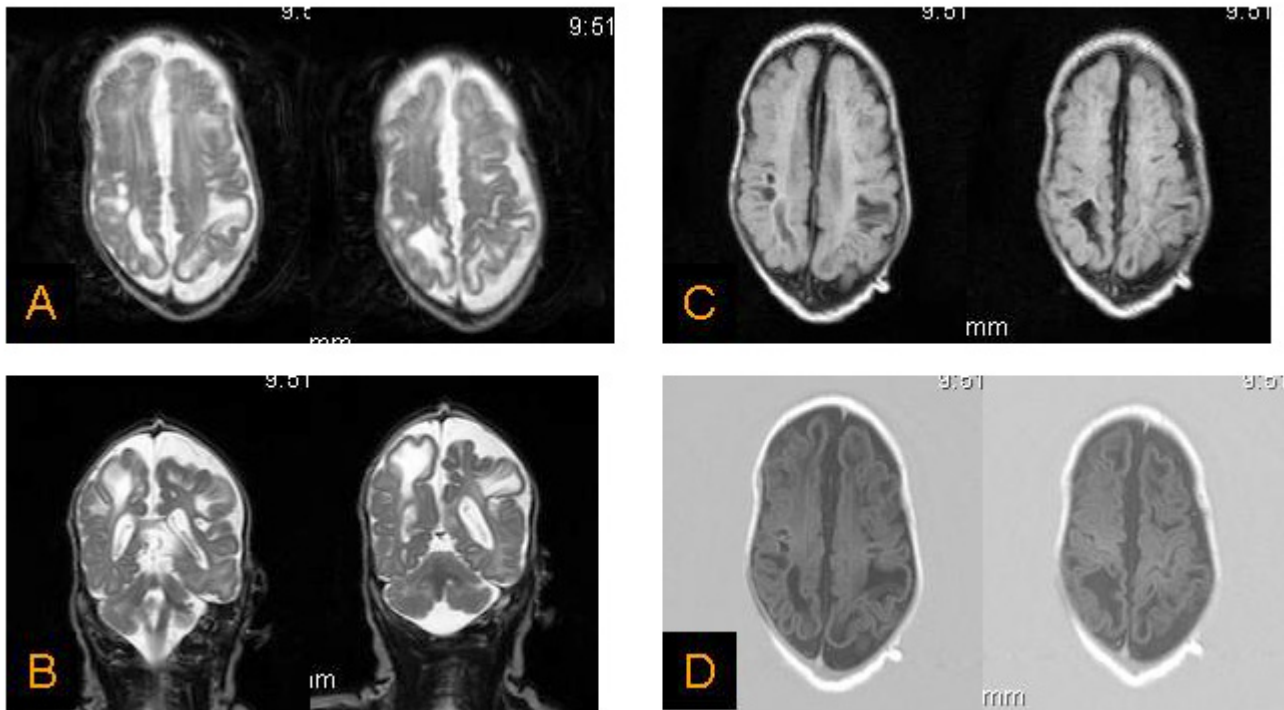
Brain MRI shows widespread posterior predominant subcortical cystic white matter changes and white matter hyperintensities. (A) T2 axial images (B) T2 coronal images (C) FLAIR images (D) T1 inversion recovery images
